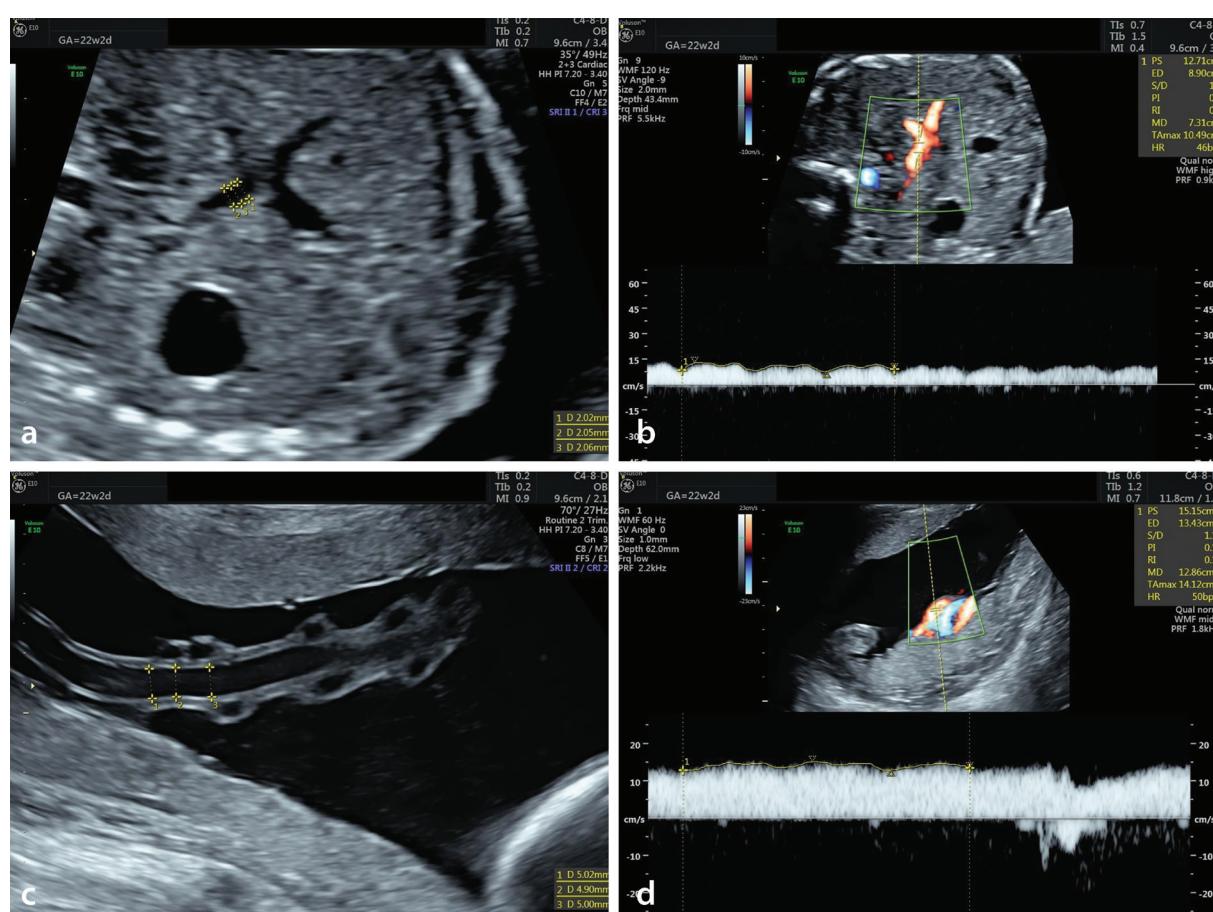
Measurements of main portal vein and umbilical vein diameters (a, b) and corresponding pulsed-wave Doppler analyses obtained transabdominally (c, d).
